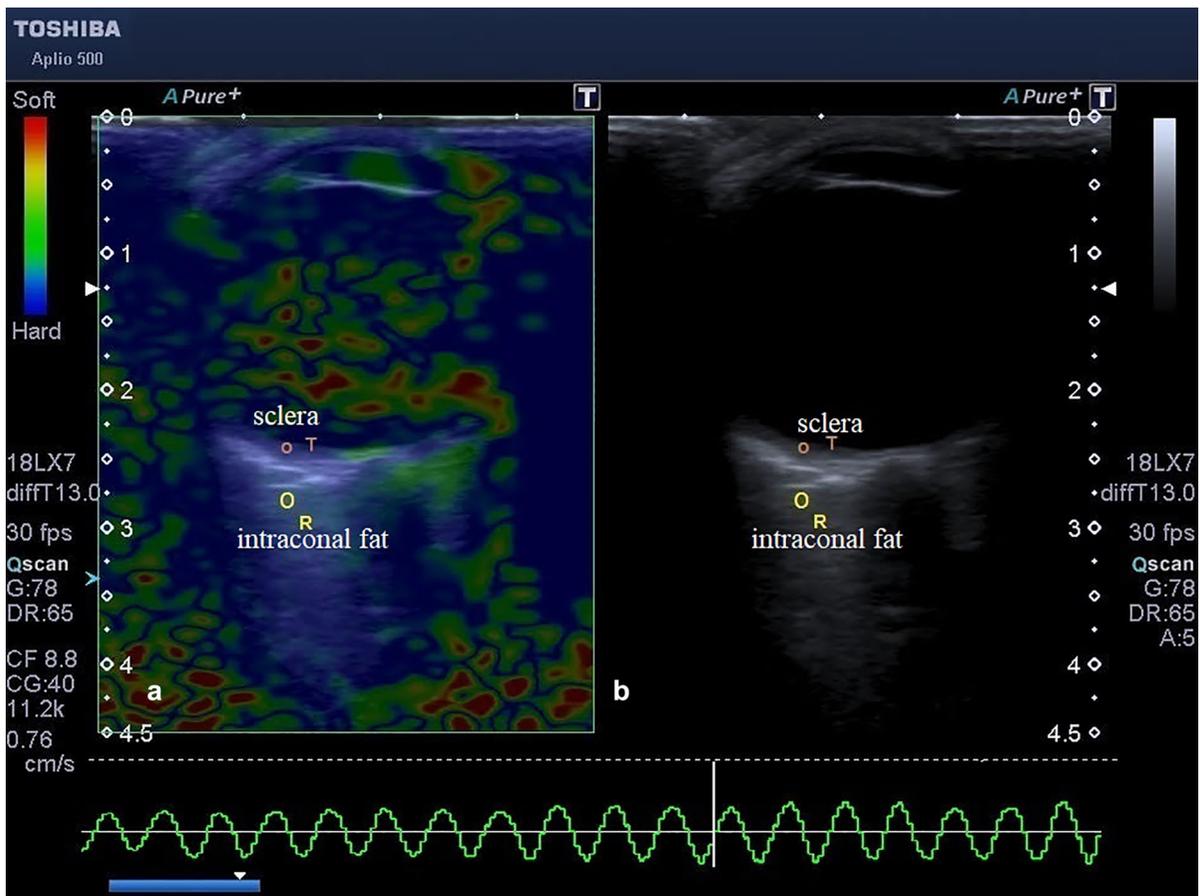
B-mode ultrasonography image (b) and the related elastography image (a) of scleral tissue (*T*) versus intraconal fat (*R*). The circles (*T* and *R*) indicate where the elastographic measurements were taken. *R* intraconal fat, *T* sclera tissue
